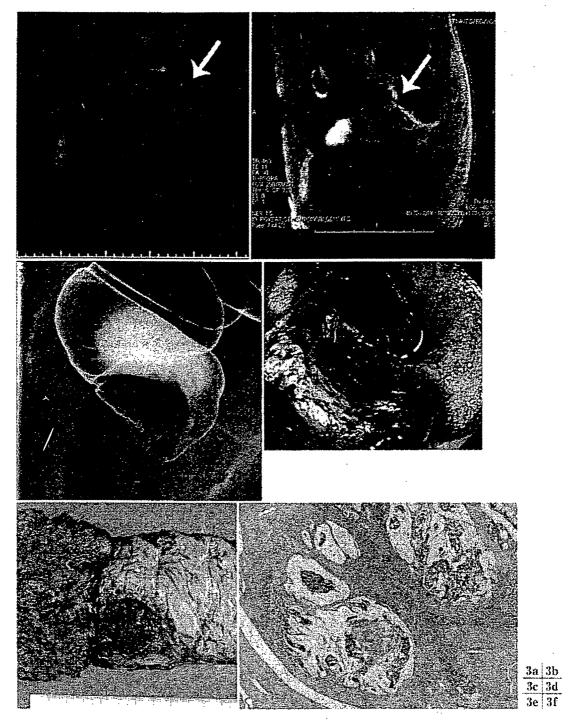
直腸癌側方リンパ節転移症例の FDG-PET
